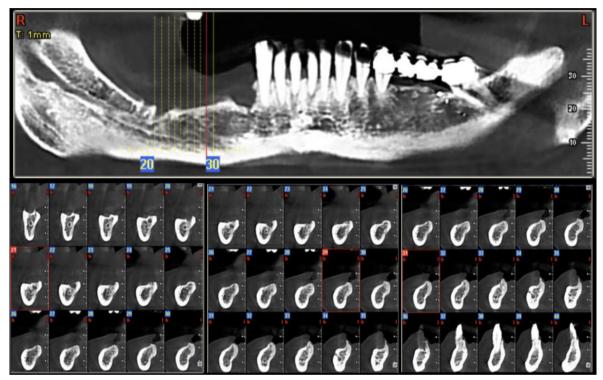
CBCT evaluation the horizontal bone defect and the donor site choosing.
